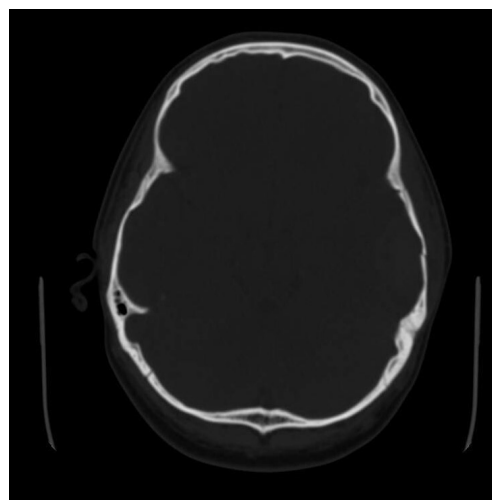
Cranial CT-scan (bone window) revealing left temporal fracture slightly misaligned.
